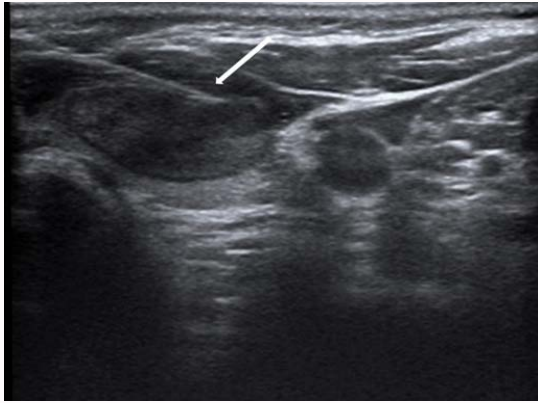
Ultrasound control of the needle path. The very hypoechoic portion was targeted (arrow).
